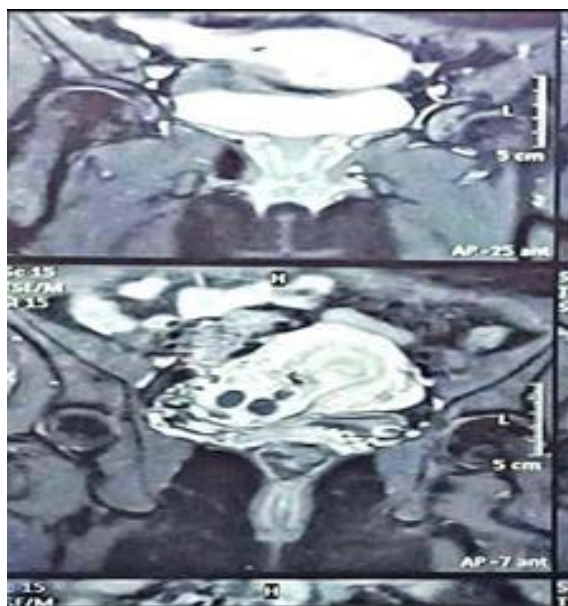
MRI image of twin ectopic gestation in cesarean scar
